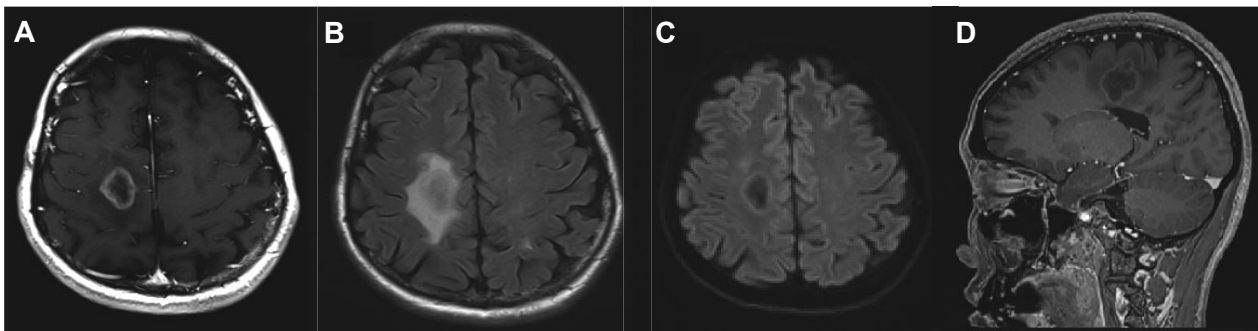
Right temporal tumor-like lesion: (A) A 2 cm ring enhancing lesion under postcontrast T1-weighted axial MRI. (B) T2-FLAIR axial MRI showing perilesional edema. (C) Diffusion-weighted axial sequence showing no diffusion restriction. (D) Ring enhancing lesion under postcontrast T1-weighted sagittal MRI.
